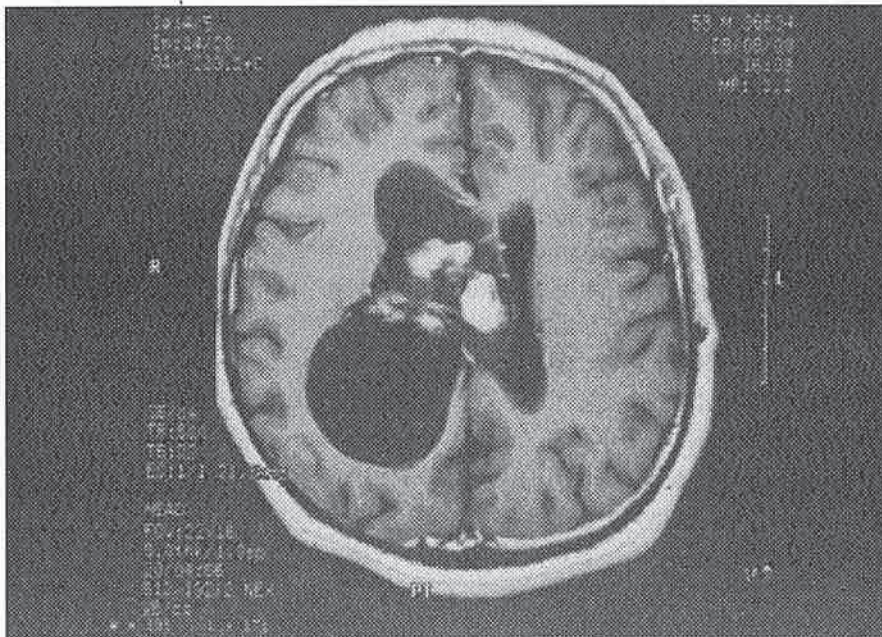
Gadolinium enhanced T1-weighted image reveals marked enhancement in the solid parts of the intraventricular mass.
